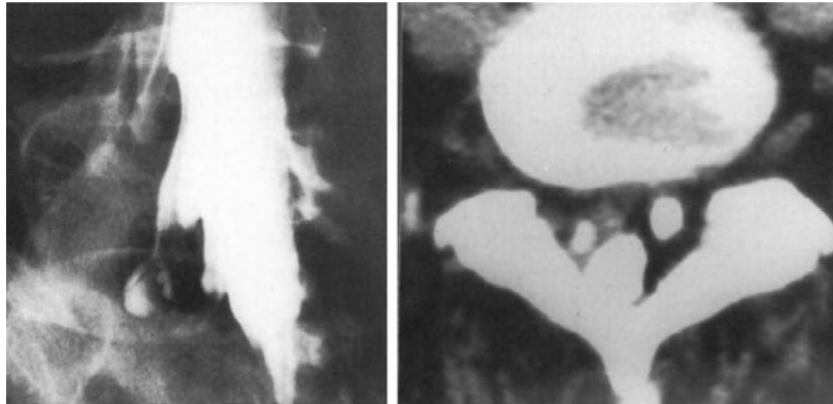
Migrated L5-S1 disc herniation on the right. The oblique myelogram shows cut-off of the right S1 nerve-root sleeve. The myelo-CT scan shows a decreased diameter of the right S1 root and intermediate density tissue between the root and the dural sac.
